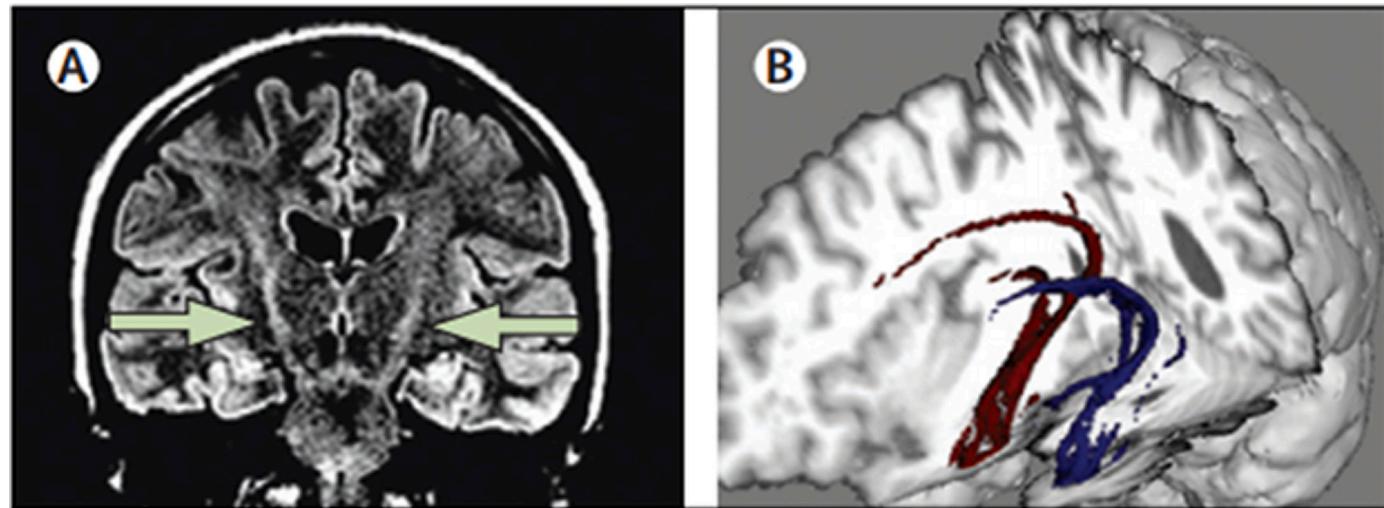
Standard v/s investigational MRI images (A) coronal view (arrows) shows hyperintense corticospinal tracts in ALS patients observed by T2-weighted fluid attenuated inversion recovery (FLAIR) sequence. (B) Diffusion tensor tractography image of superior oblique cut-out brain section (viewed from left) shows lesser white matter projection fibers on left (blue) side as compared to the right (red) side in an ALS patient with unusual phenotype such as prominent aphasia and refurbishment of the temporal lobe white matter projection fibers.
